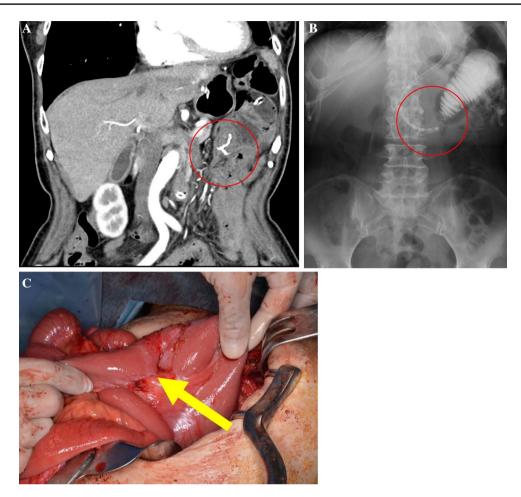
The imaging and intraoperative photographs of a case of bowel obstruction after antiperistaltic stapled side-to-side anastomosis. a A computed tomography scan shows a caliber change near the stapled anastomotic site. b Radiography with contrast also shows
